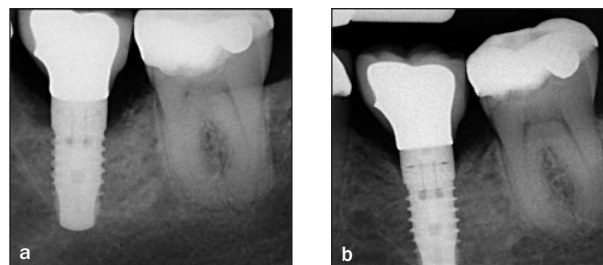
Radiographic images of second representative case. (a) Preoperative and (b) 12-month postoperative presentation.
